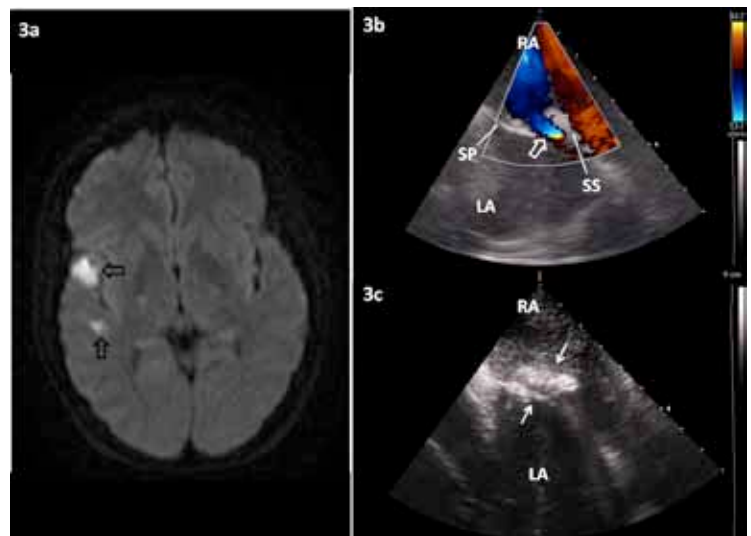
A 21-year-old non-smoking lady who did not have any pro-thrombotic risk factors or coagulopathy presented with transient left sided weakness lasting a few hours. An MRI of head a) confirmed the presence of two lesions consistent with infarction (black open arrows) and TEE confirmed the presence of a PFO with right-to-left shunt on Valsalva manoeuvre. She was started on aspirin therapy and participation in REDUCE trial was discussed with her. She gave informed consent and was randomised to PFO closure using Helex® septal occluder plus antiplatelet therapy. Under ICE and fluoroscopy guidance, b) the PFO measured 8 mm in diameter with an 11-mm tunnel on balloon sizing. This was c) successfully closed with a 25-mm Helex® septal occluder without residual shunt on agitated saline contrast upon release of Valsalva. LA, left atrium; RA, right atrium; SP, septum primum; SS, septum secundum.
